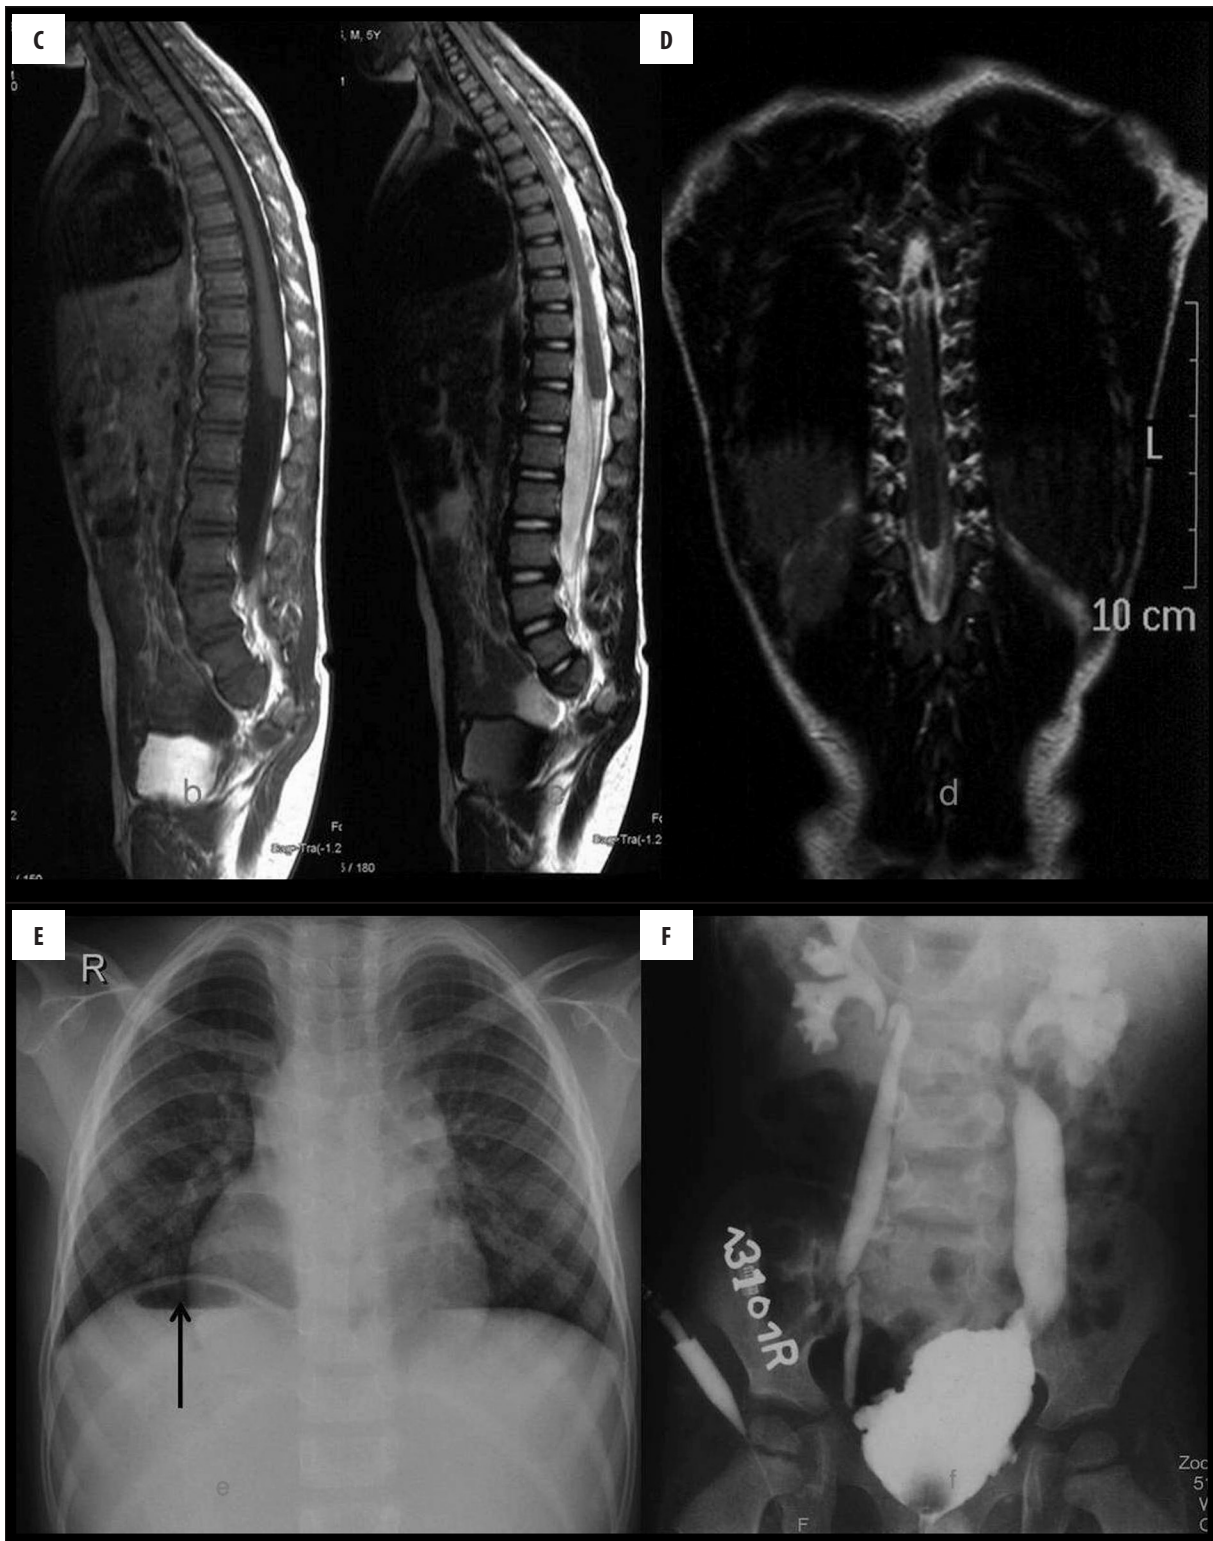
(A) Radiograph of the LS vertebral column of a 4-year-old boy revealed hypoplastic sacrococcygeal elements. (B) MRI of the LS vertebral column – (B, D) – T1W Sagittal and T2W coronal images showing a round conus with an abrupt and high termination (arrowhead). (C) The nerve roots can be followed caudally as a dual-bundle pattern (arrows). Note the hypoplasia of sacrum. (E) Chest radiograph showing dextrocardia with right-sided gastric air-fluid level (arrow) suggestive of situs inversus totalis. (F) Micturating cystourethrogram showing bilateral grade V VUR.
